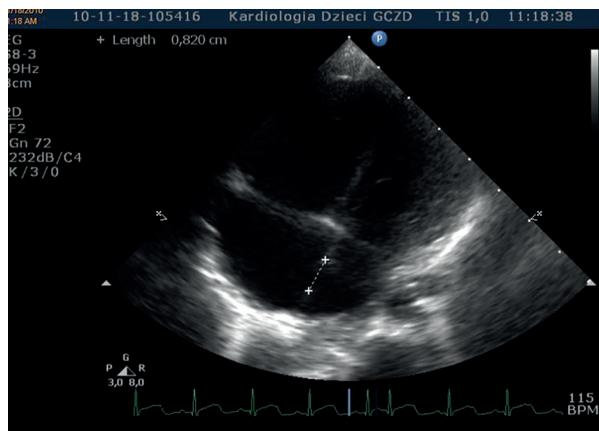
Transthoracic echocardiography 4-chamber view. Atrial septal defects 2 approx. 8.2 mm. The enlarged right atrium and right ventricle
